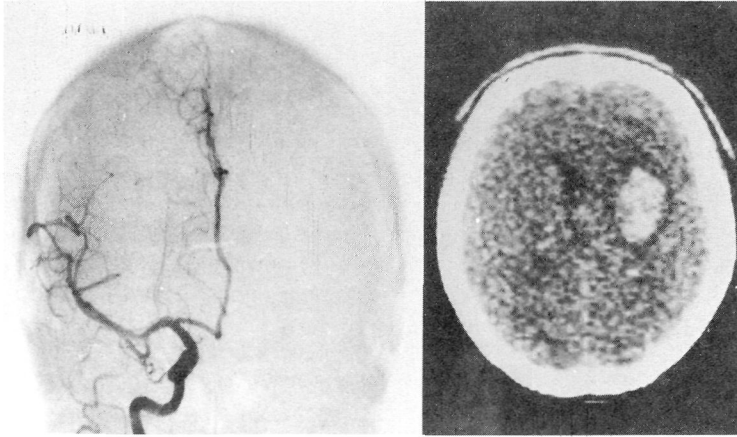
Right carotid angiogram and computed tomography in case 1 showing circulatory restoration and hemorrhagic infarction after recanalization of initially occluded middle cerebral artery at its trifurcation.
